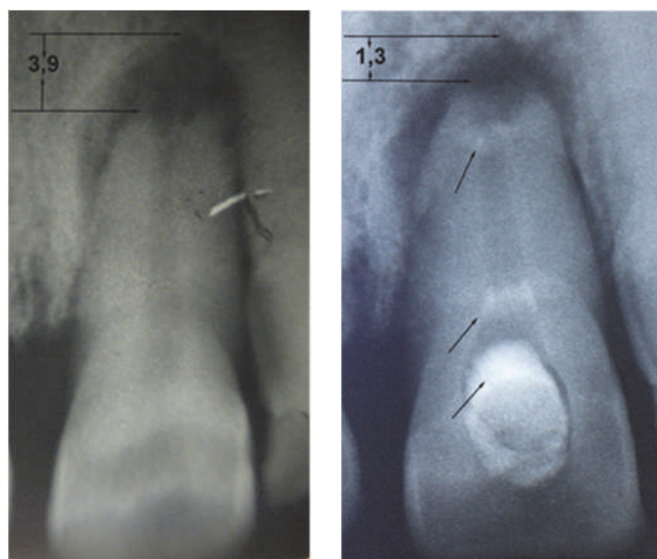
Spot dental X-ray of tooth 21 of the 52 year-old male patient T. The state of the tooth before treatment (a). The state of the tooth following 15 days after treatment (b).
